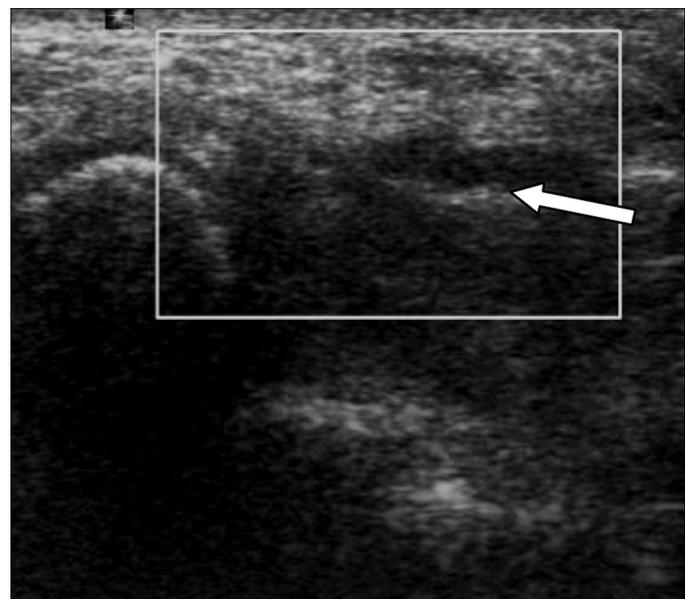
Transverse ultrasound examination of the wrist showing an enlarged median nerve at level of pisiform bone (arrow).
